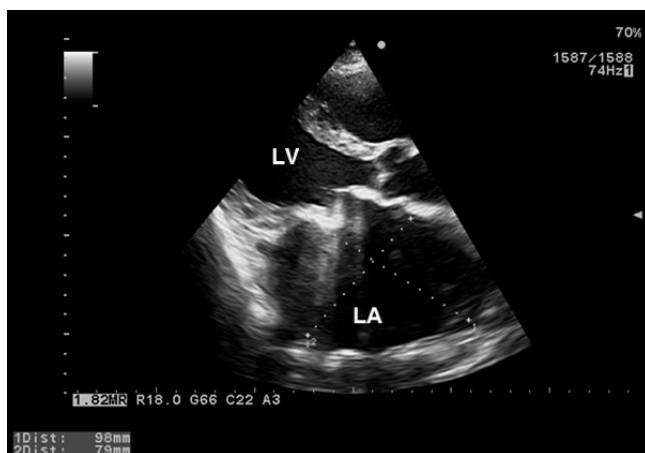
Transthoracic echocardiogram (parasternal short-axis view) of the left atrium (LA).
